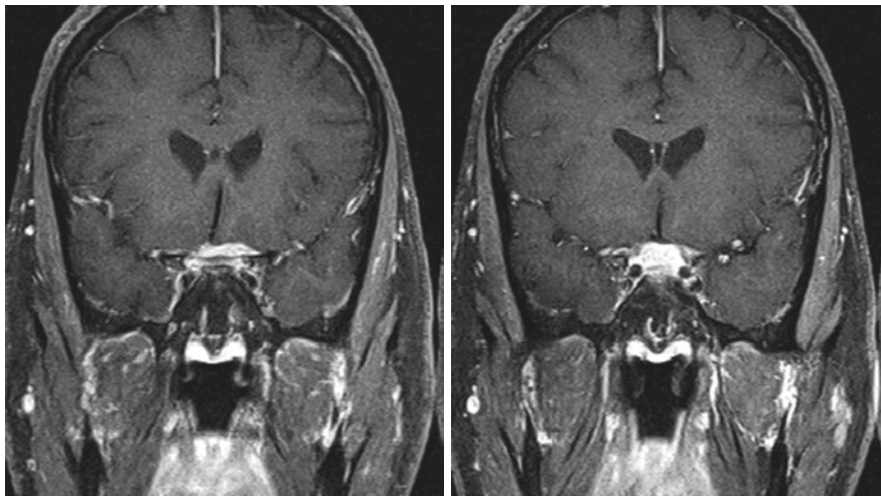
Coronal T1-weighted MRI with fat saturation and gadolinium shows enhancing dural mass compressing the chiasm and intracranial optic nerves on the right more than the left. Meningeal tail was also present posteriorly (not shown). (© AG Distefano 2020. All Rights Reserved)
